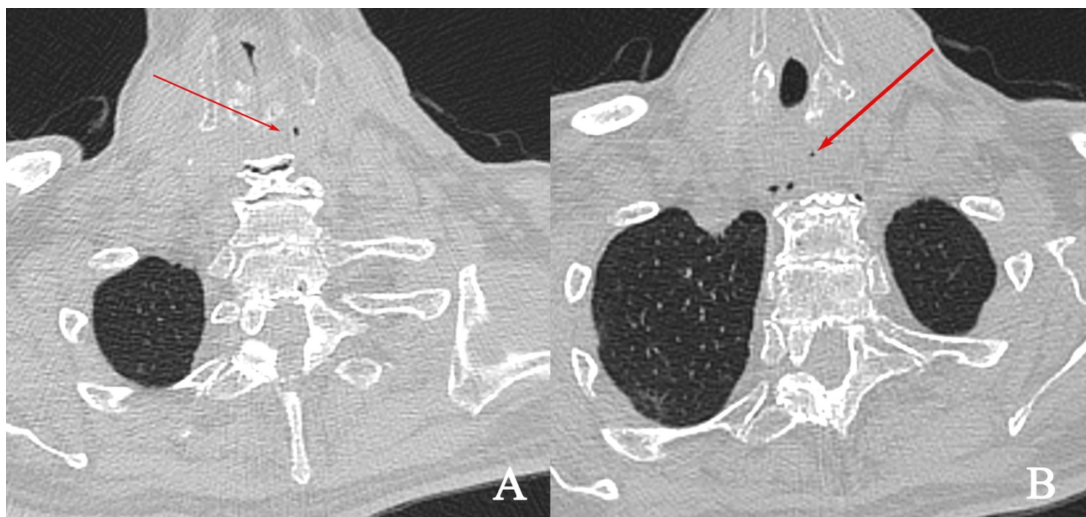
Computed Tomography (CT). The arrows (A; B) show the presence of ectopic air along the esophageal wall, indicating a possible perforation.
